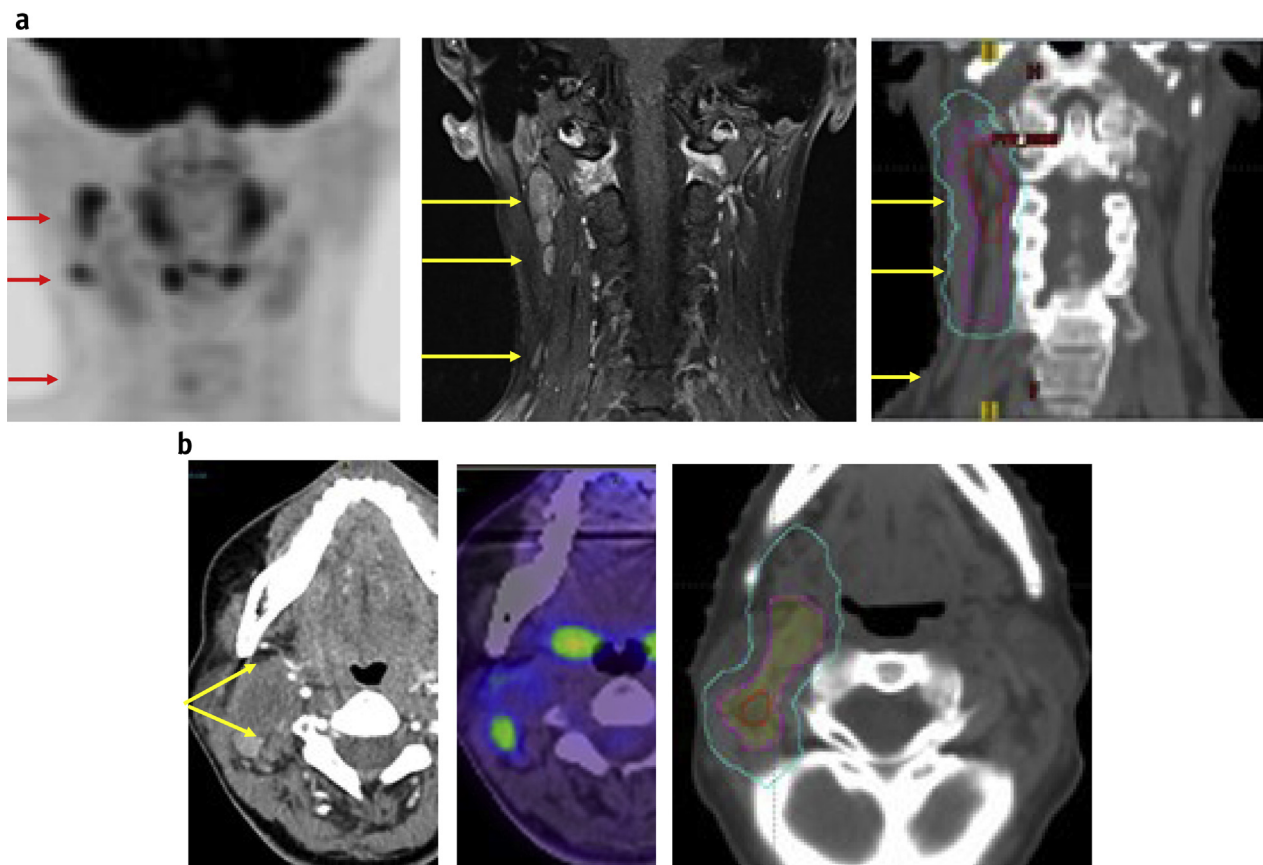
Stage I diffuse large B-cell lymphoma treated with 3 cycles of R-CHOP and involved site radiation therapy: (a) Coronal positron emission tomography and magnetic resonance imaging demonstrate upper and midneck nodes. Lower right neck node is nonenlarged and fluorodeoxyglucose negative and excluded from the clinical target volume (CTV); (b) nodal mass is partly positron emission tomography negative (arrows) with ill-defined boundaries. The CTV includes all initially suspicious tissue.
